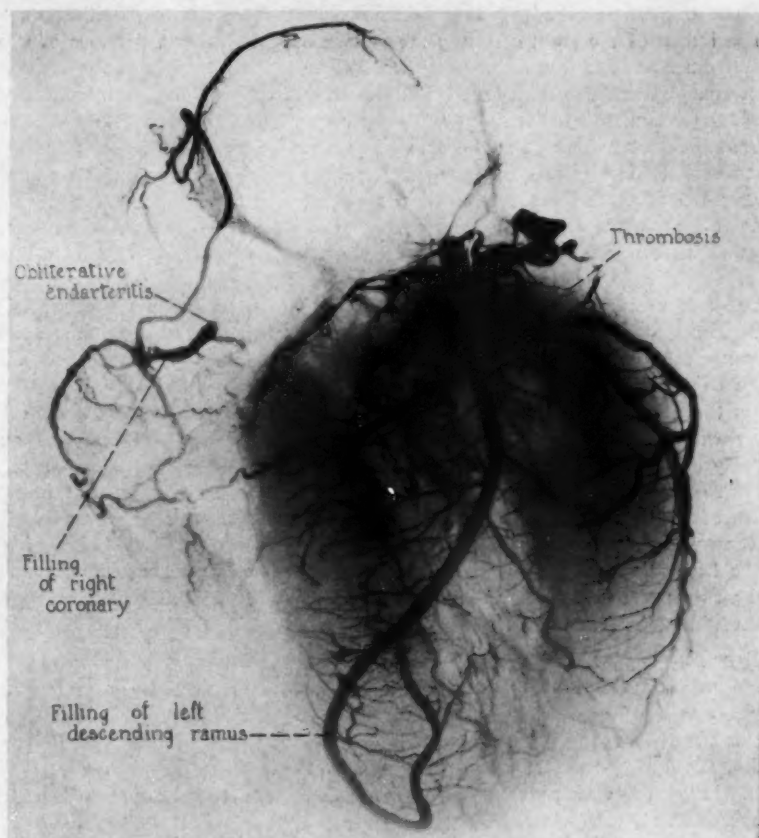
(case 4).—Roentgenogram of the heart injected through the left coronary orifice. There is complete obliteration of the proximal portion of the right coronary artery and thrombosis of the descending ramus of the left.
